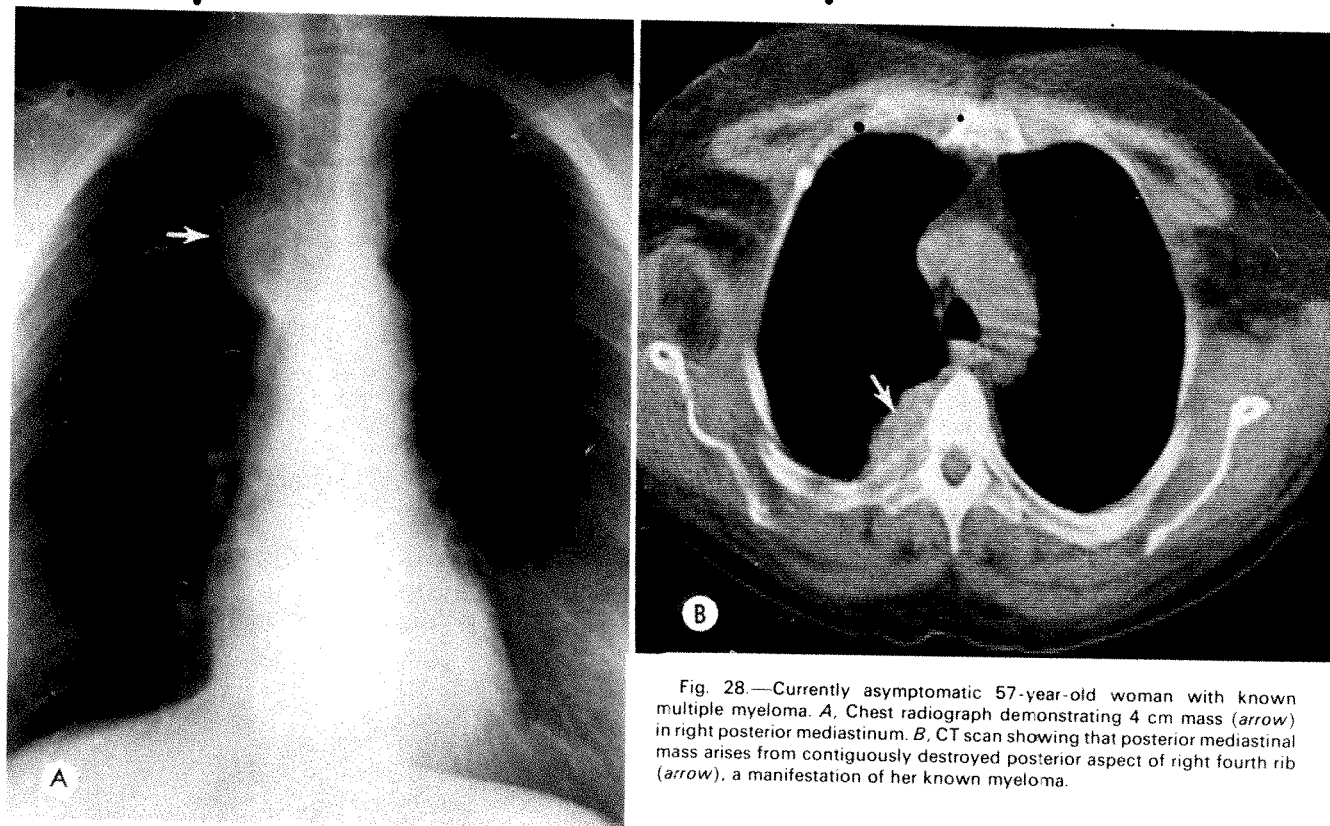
Currently asymptomatic 57-year-old woman with known multiple myeloma. *A*, Chest radiograph demonstrating 4 cm mass (arrow) in right posterior mediastinum. *B*, CT scan showing that posterior mediastinal mass arises from contiguously destroyed posterior aspect of right fourth rib (arrow), a manifestation of her known myeloma.
